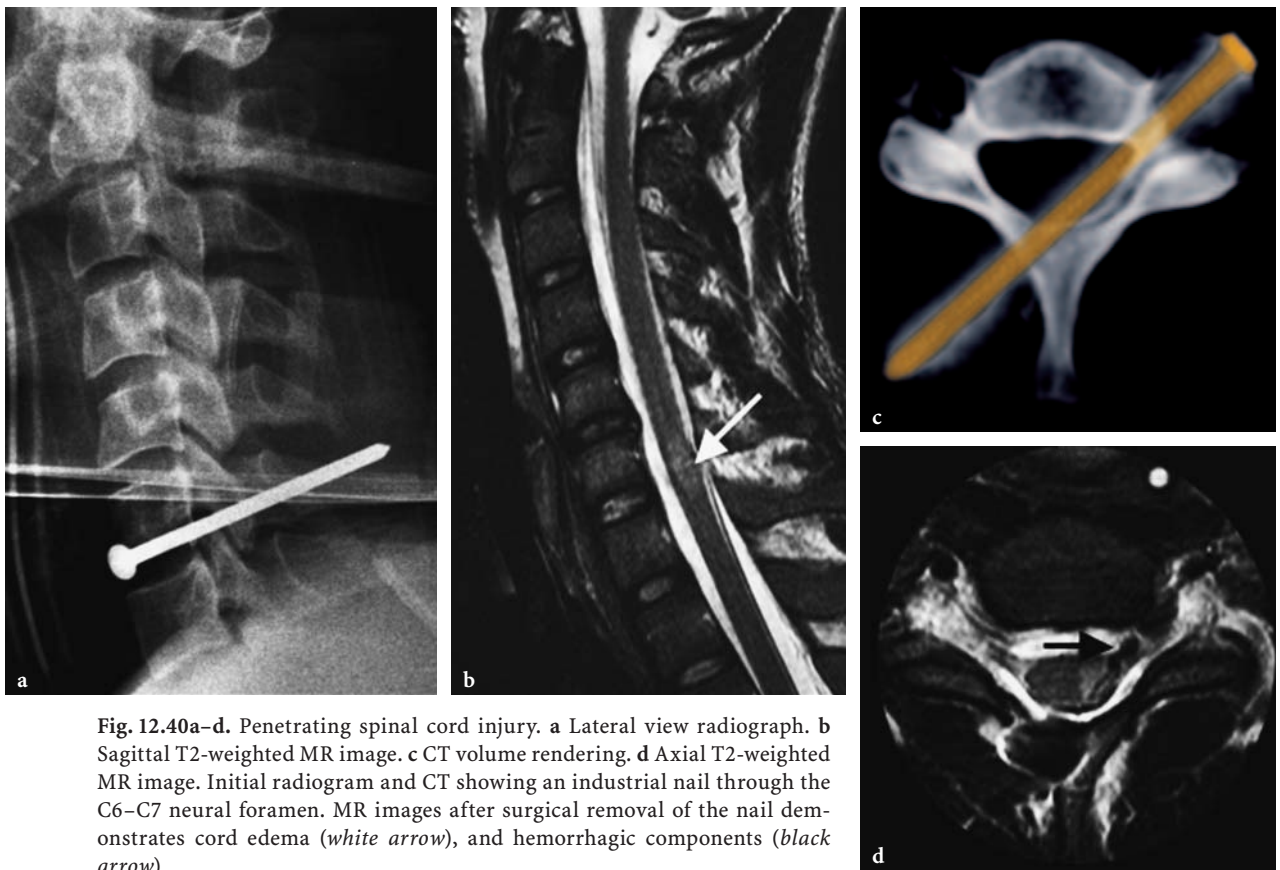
Penetrating spinal cord injury. a Lateral view radiograph. b Sagittal T2-weighted MR image. c CT volume rendering. d Axial T2-weighted MR image. Initial radiogram and CT showing an industrial nail through the C6–C7 neural foramen. MR images after surgical removal of the nail demonstrates cord edema (*white arrow*), and hemorrhagic components (*black arrow*)
